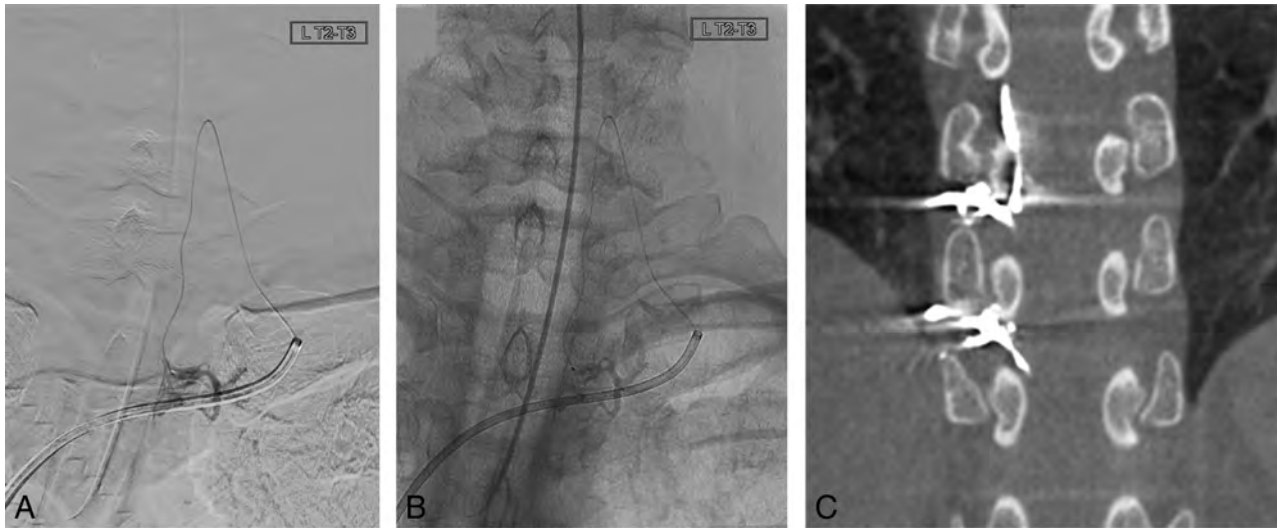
Examples of the appearance of the lateral epidural space at different levels. Subtracted (A) and unsubtracted (B) microcatheter venography performed at the left T2 lateral epidural plexus fills the foraminal veins. In this case, the guide catheter is in the left brachiocephalic vein. The microcatheter enters the left C6 foramen via the vertebral vein, before forming a hairpin turn and traveling caudally across 3 levels through the lateral epidural plexus. C, Postembolization conebeam CT in a different patient shows the embolic agent within the right T8 and T9 foraminal veins and the adjacent lateral epidural plexus.
